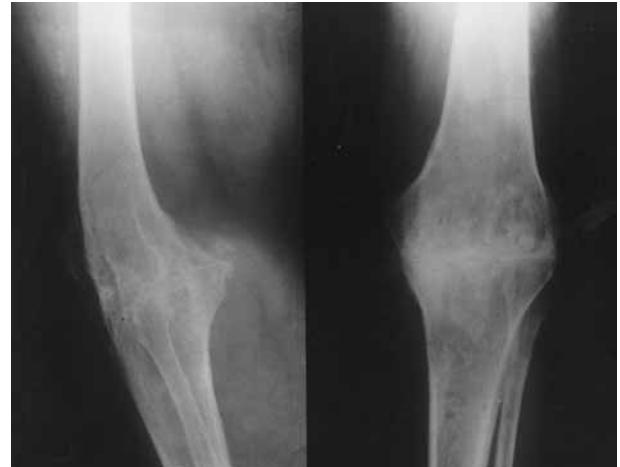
Radiographs of a 58-year-old female who underwent knee arthrodesis using the Ilizarov frame owing to an infected failed total knee arthroplasty. Solid fusion was achieved within eleven weeks.
